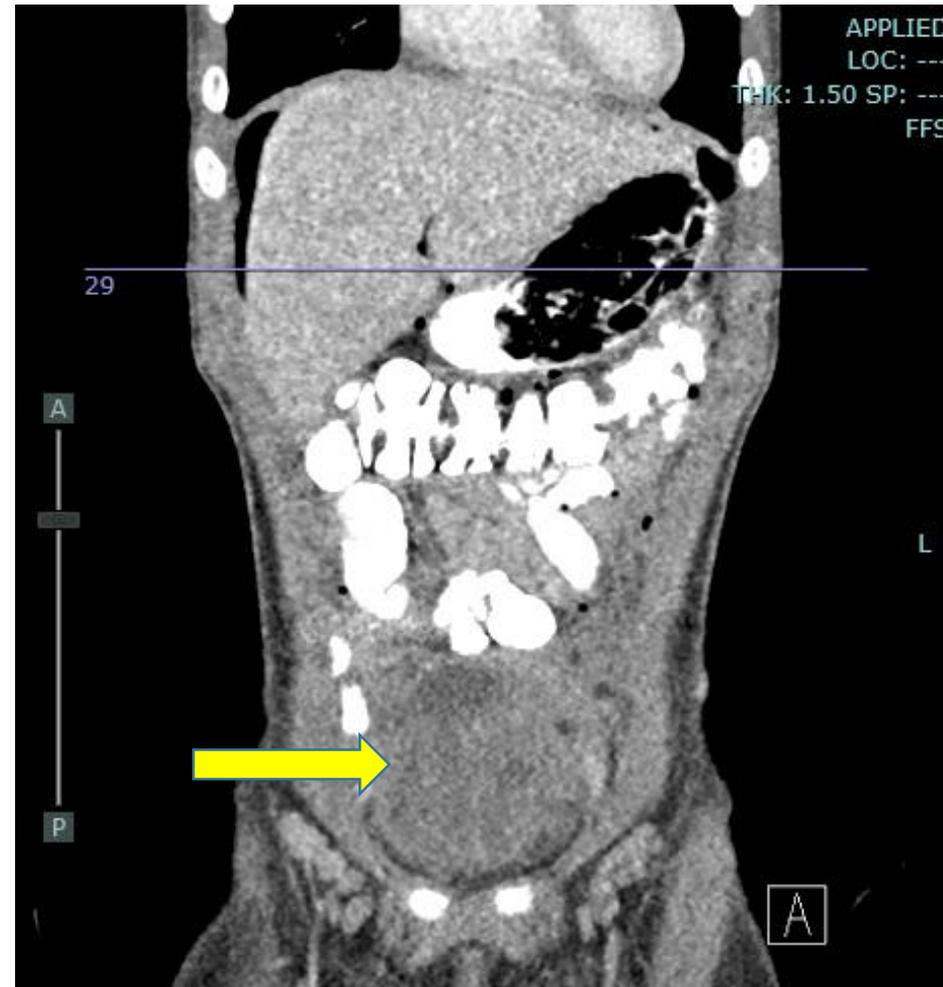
Coronal view – CT abdomen/pelvis with IV and PO contrast
